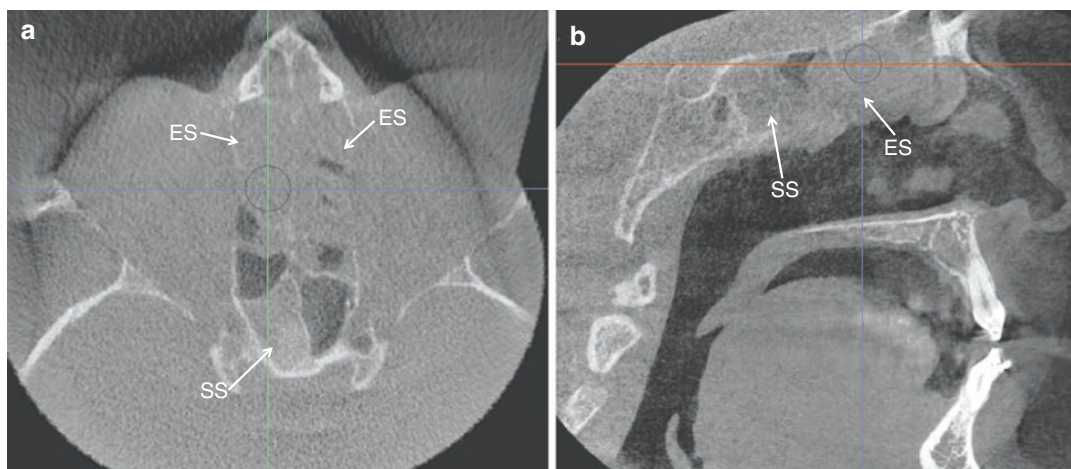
Axial (a), coronal (b) CBCT sections of the ethmoid sinuses showing presence of soft tissue hypodensity in several air cells (*arrows*) consistent with ethmoid sinus inflammatory changes
